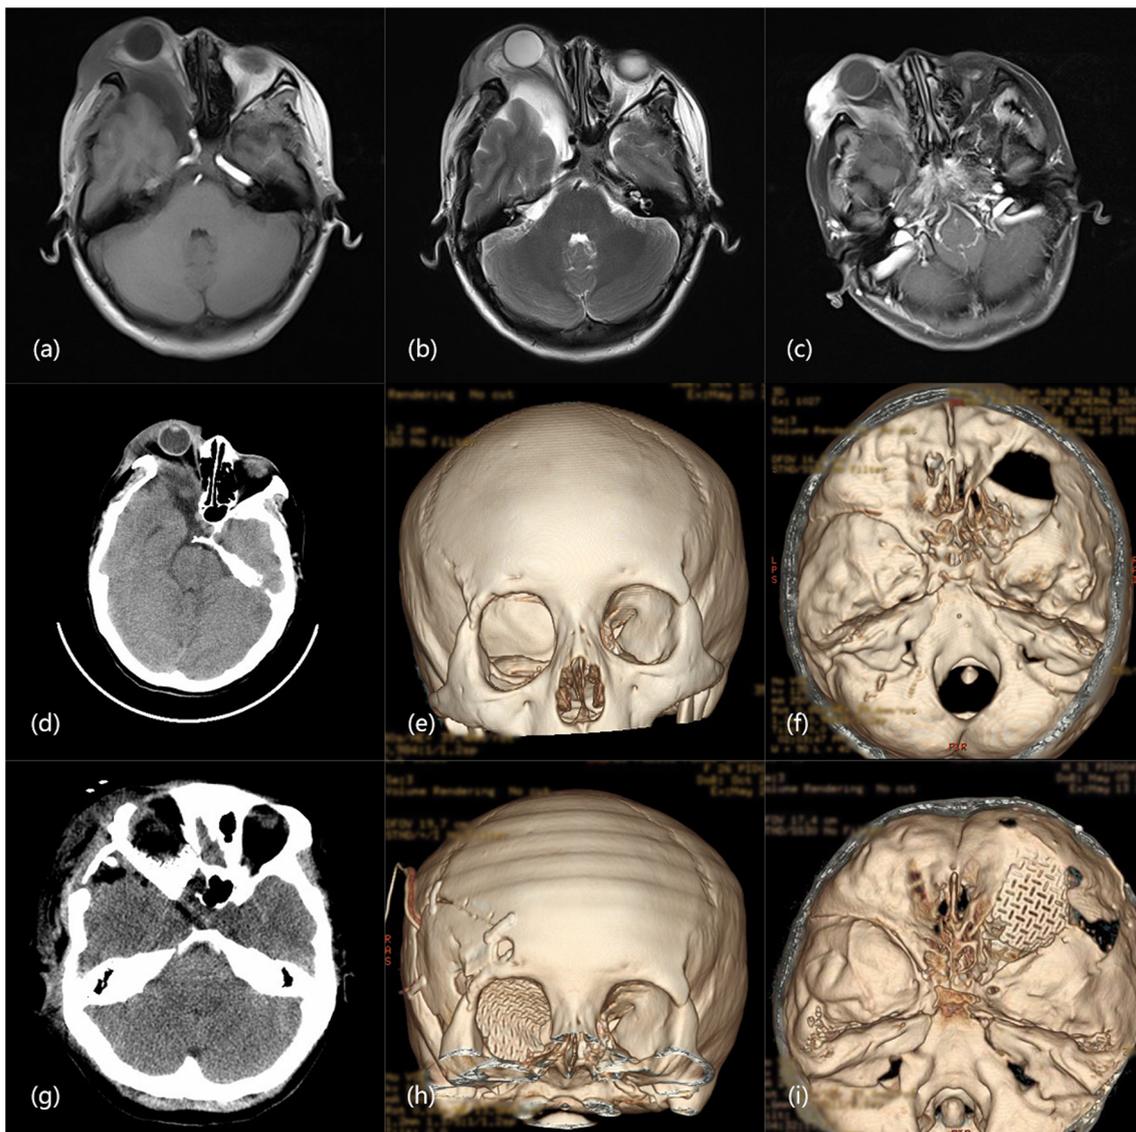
Imaging features (preoperation and postoperation) of case 18: a (T1-weighted MRI image), b (T2-weighted MRI image) showing the significantly widened subarachnoid space in the right temporal pole, which enters in the right eye socket to compress the extraocular muscles, and the right eyeball obviously protruding outward; c Enhanced MRI scan showing significant enhancement of plexiform lesions in the right eyelid and orbit; d Plain CT scan of the head showing the absence of the right greater wing of the sphenoid bone; e Anteroposterior view of the three-dimensional skull reconstruction of the head CT showing oval enlargement of the right orbit and obvious defects
